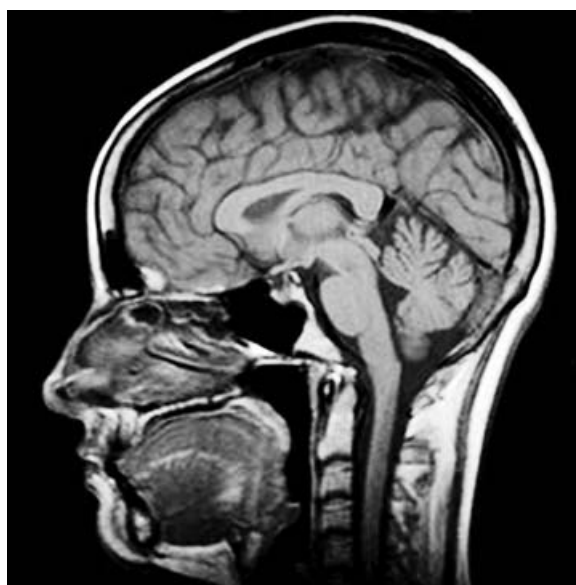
Normal sagittal T1 MRI. The CSF is black on T1 images, since water is free to move about and release its proton-labels distant from where they were applied. Bone is also black, but only because it contains little water. The image shows both cisterns and the ventricular system as either black or gray.
